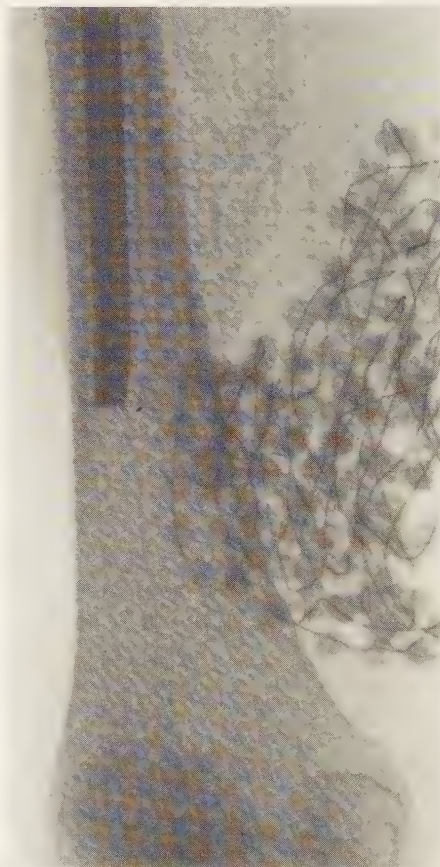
Radiographic examination showing 60 gentamicin beads inserted into the cavity adjacent to the femoral fracture.
